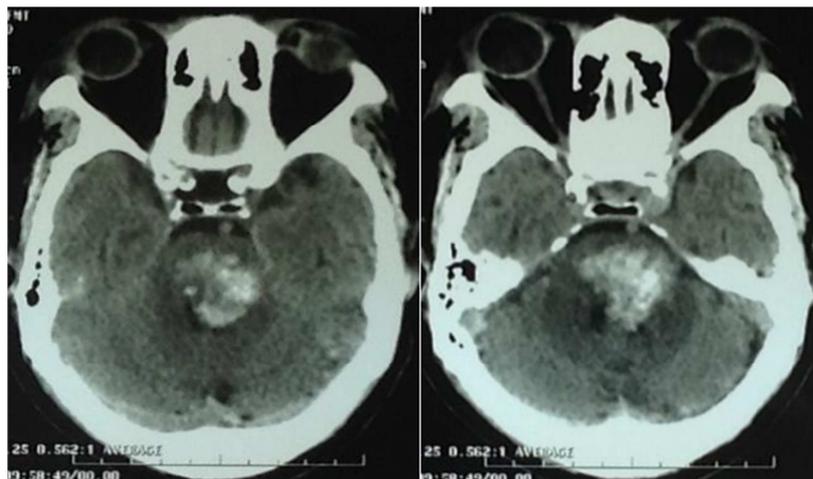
CT-scan shows an extensive massive bulbo-pontic hematoma.
